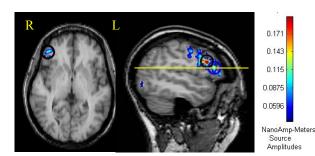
MRI scan with cortical activation located in Broca's area (BA 45 and 46) seen at 438ms after onset of visual stimuli. This is the same subject in fig 2 while using the SpeechEasy device. Note higher source amplitudes and larger areas of activation in the IFG compared to figure 2. Yellow line indicates axial slice.
